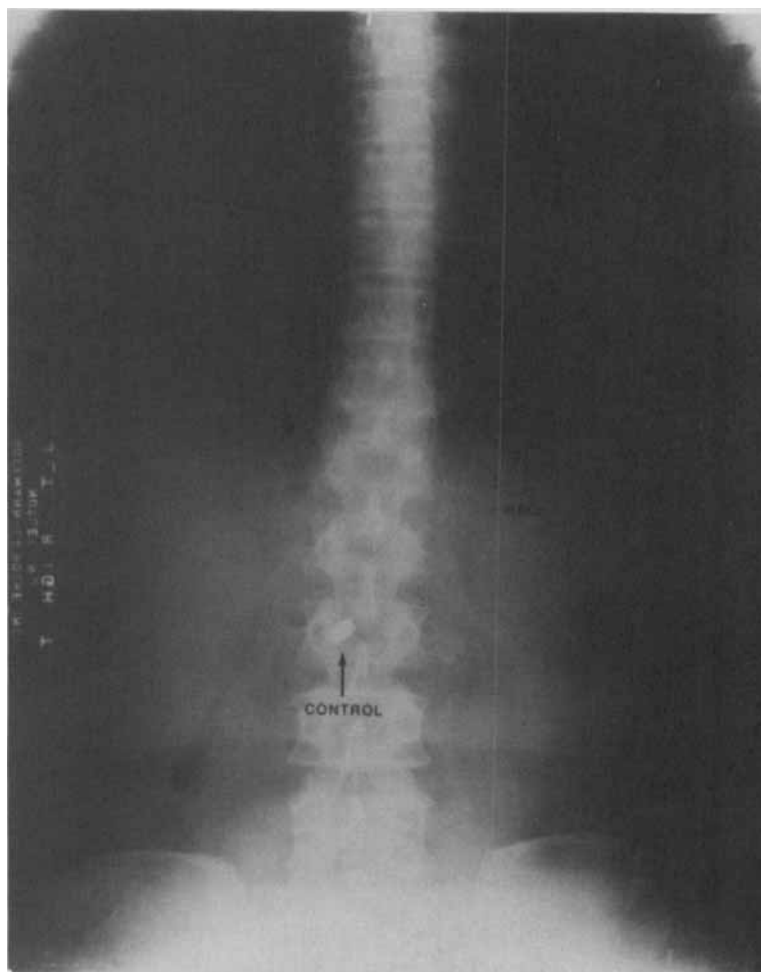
X-ray of HBS capsule and conventional capsule (control) in human subject after simultaneous ingestion.
